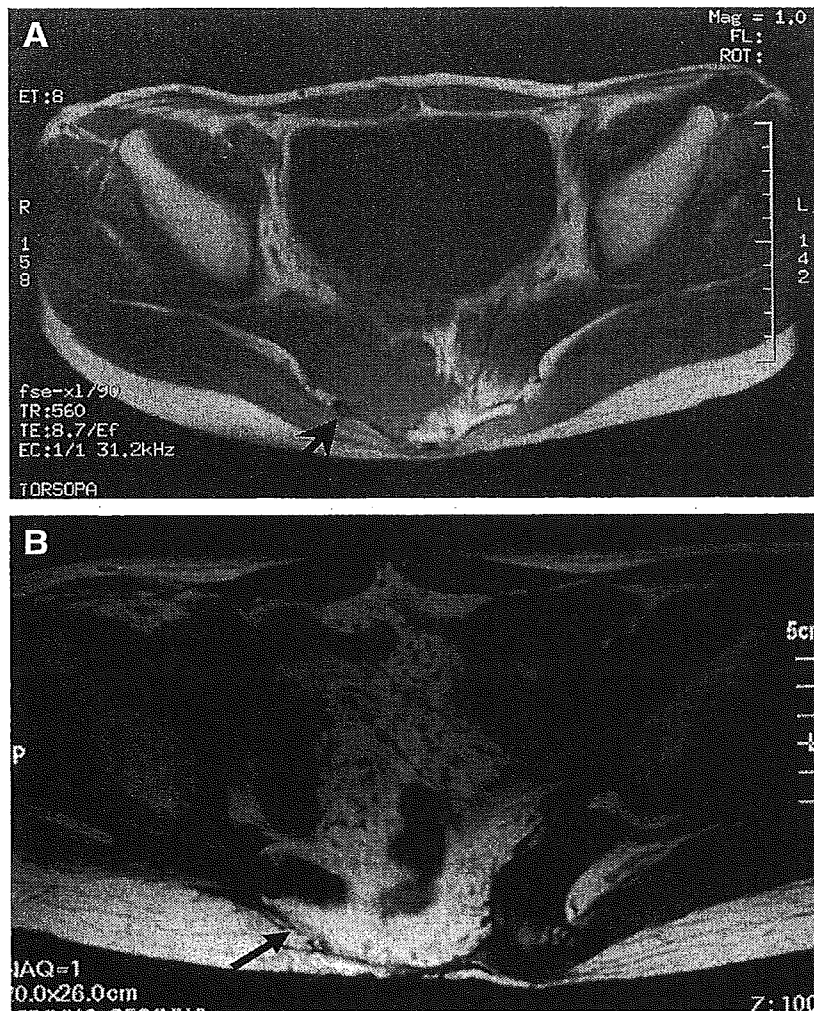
(A) Dorsolateral pelvic recurrence with sacral bone invasion. A 47-year-old male patient underwent TPES for his FRT (arrow) with 673 mL blood loss and no complication. At initial surgery 1.5 years ago, he received low anterior resection. (B) Postoperative MRI. The patient is alive without re-recurrence 4 years after TPES.
